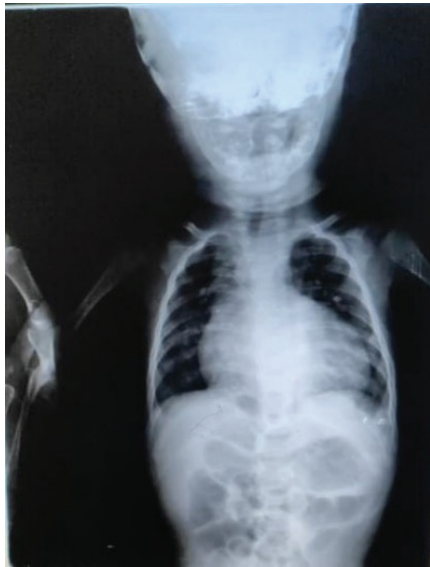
Chest radiography revealed increased pulmonary vascular markings and the classic “egg-on-a-string” cardiac silhouette.
